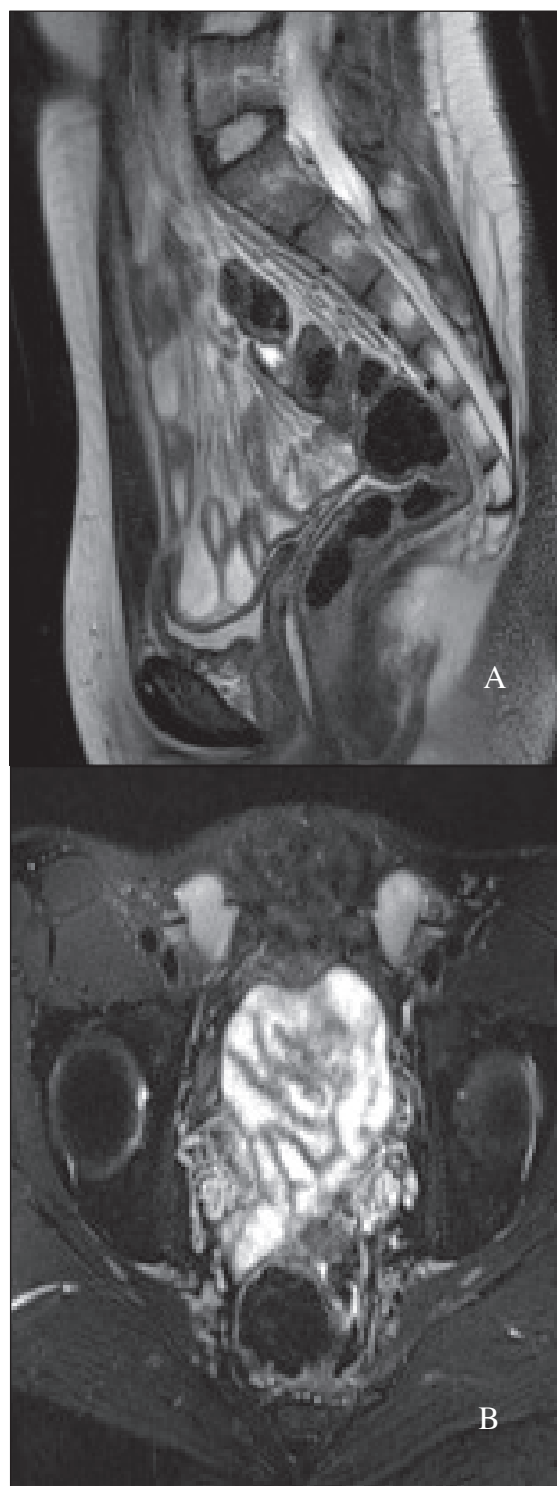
A T2-weighted magnetic resonance image (MRI) of the pelvis, showing no uterus and (B) testicles within the inguinal canals (arrows) in a patient with complete androgen insensitivity (CAI)
